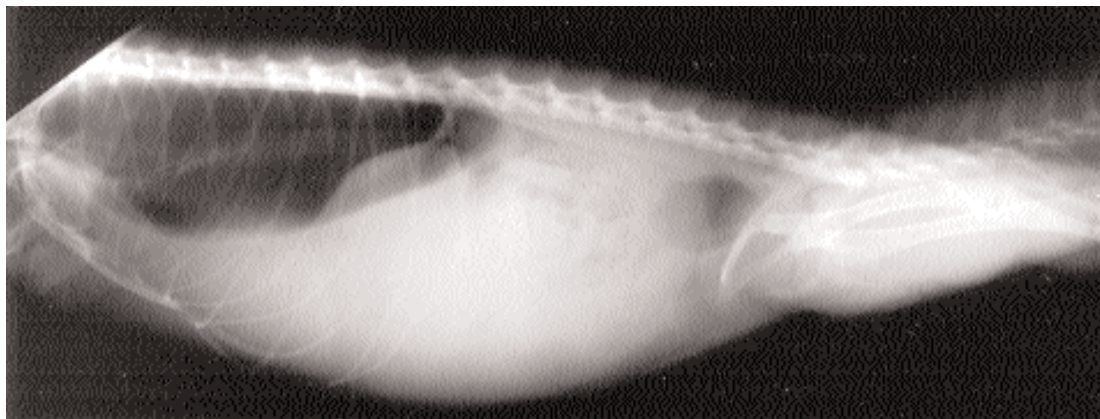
Right lateral radiographic view of the same iguana at re-presentation, as in Figure 2.
